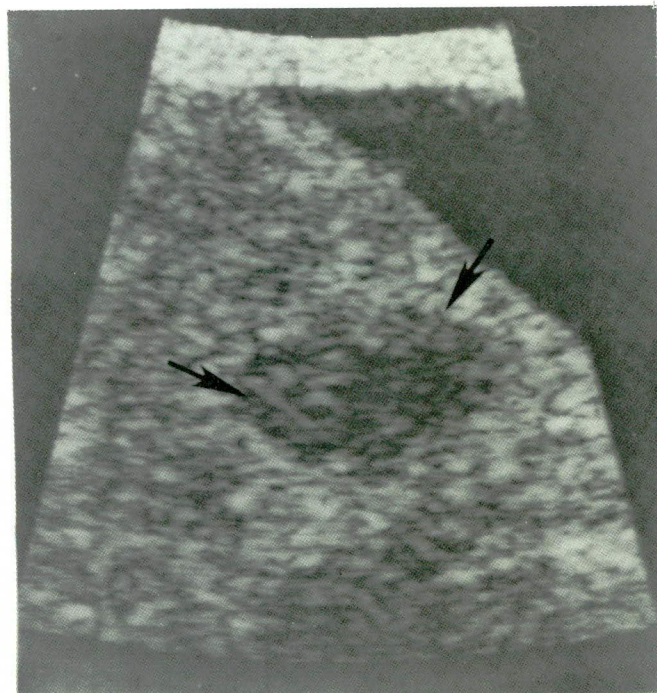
Lymphoma of the testicle. An 18-year-old male with lymphoblastic lymphoma presenting with bilaterally enlarged testicles and retroperitoneal adenopathy. Transverse sonogram shows one of the hypoechoic nodules (arrows).
